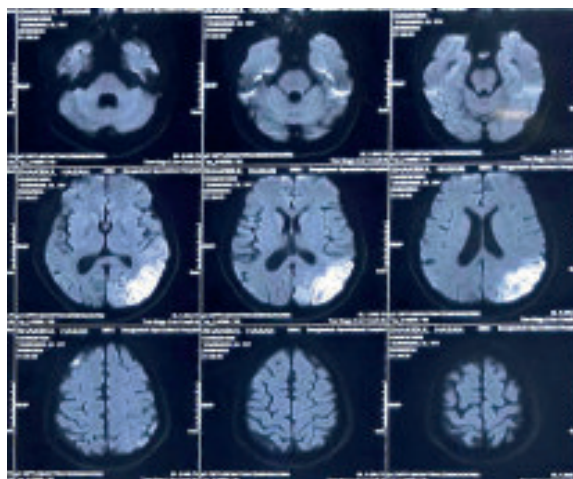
Magnetic resonance imaging of brain (DWI sequence) showing hypointense shadow in left occipital lobe
